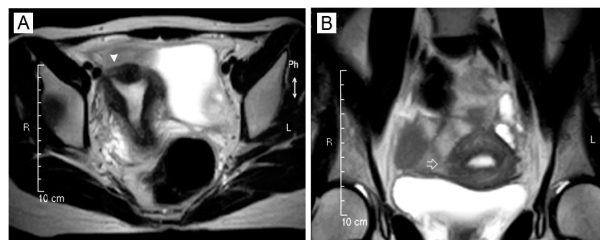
Magnetic resonance images that were obtained 3 months following laparoscopic cornuotomy for interstitial pregnancy. (A) Axial view on the T2-weighted image; (B) Coronal view on the T2-weighted image. The arrowhead and opened arrow indicate the affected cornu. Note that there are no significant differences in the thickness of the affected and unaffected cornu, and no defects in terms of the overall cornual contour (case no. 2).
